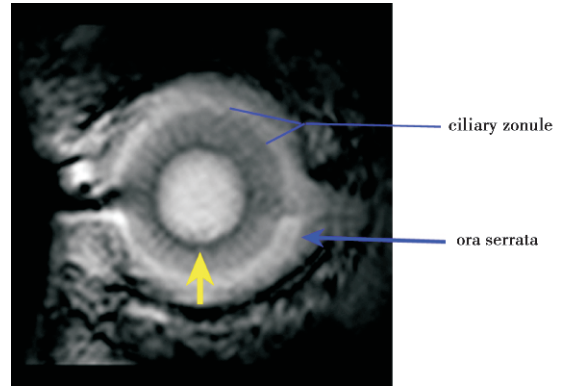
Coronal FFE sequence T₁WI HR-MR image. The layers of the ocular wall fine anatomy are depicted.iris (yellow arrow)
